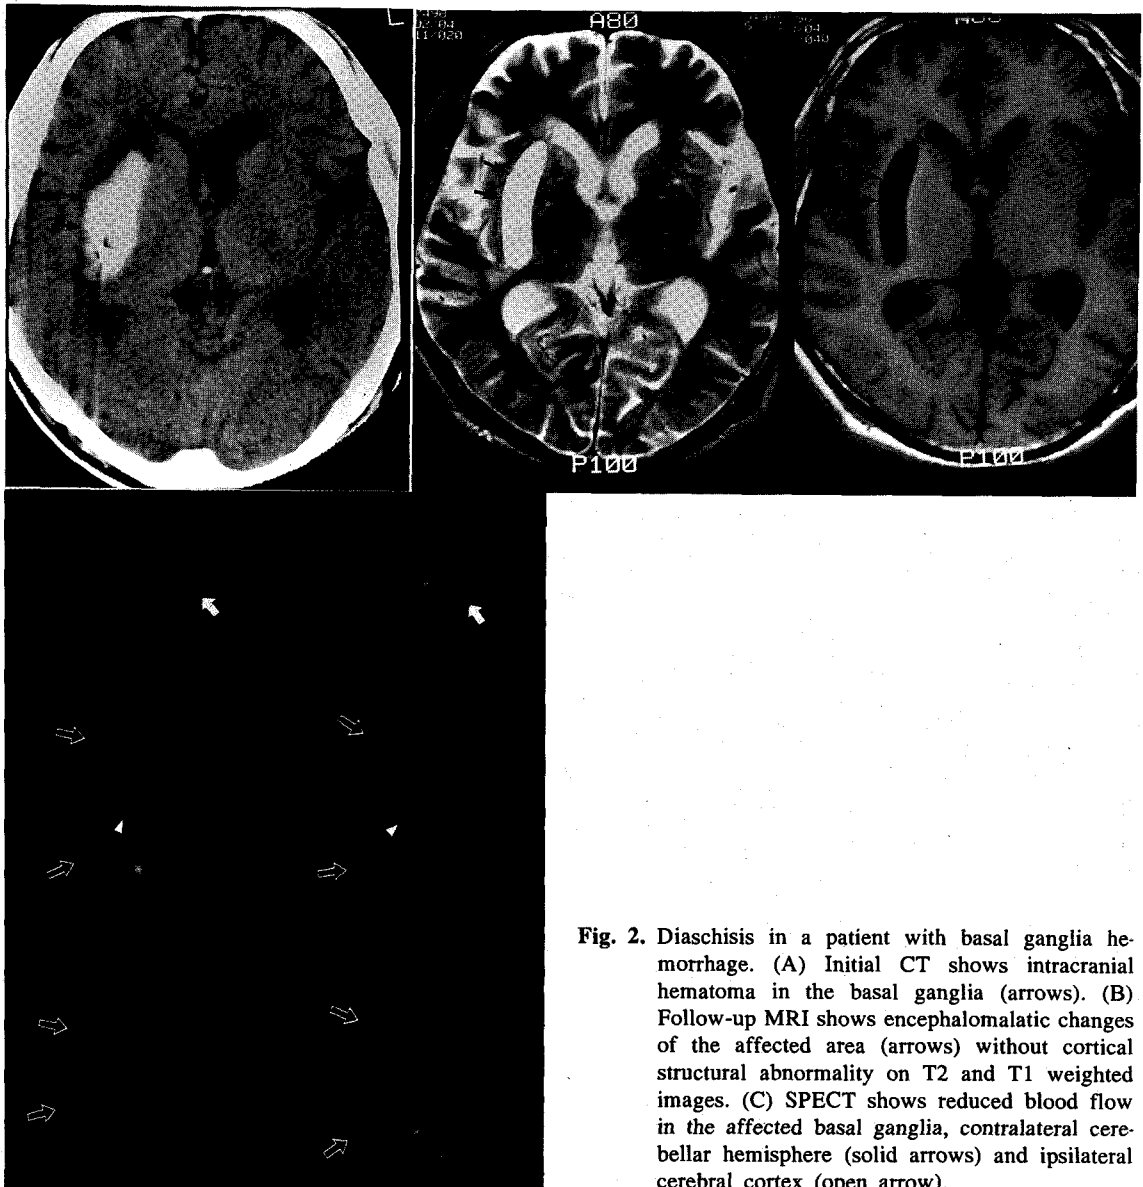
Diaschisis in a patient with basal ganglia hemorrhage. (A) Initial CT shows intracranial hematoma in the basal ganglia (arrows). (B) Follow-up MRI shows encephalomalacic changes of the affected area (arrows) without cortical structural abnormality on T2 and T1 weighted images. (C) SPECT shows reduced blood flow in the affected basal ganglia, contralateral cerebellar hemisphere (solid arrows) and ipsilateral cerebral cortex (open arrow).
